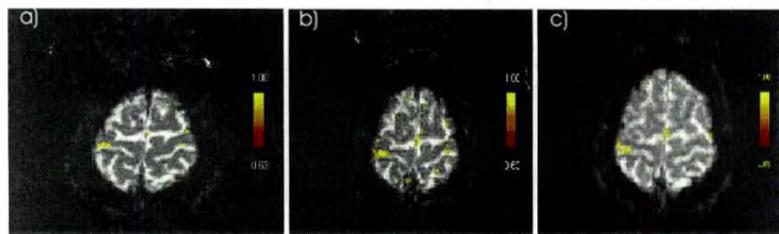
Cortical activation within the primary motor and the primary sensory area MI/SI a) prior to DWI, b) immediately after DWI and c) one week after DWI. An increase of activation is seen bilaterally within the MI/SI and ipsilaterally to the tapping hand within the premotor area PM. One week after DWI the changes of activation signal in CMT study disappeared and an activation pattern similar to the baseline study was found.
